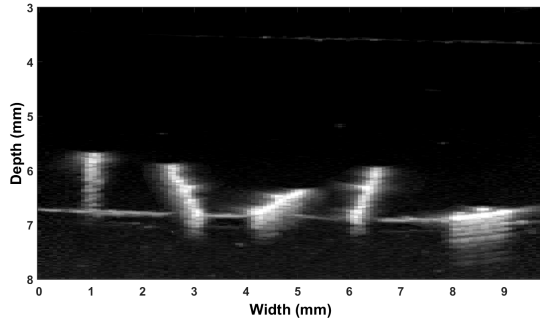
in vitro* Tests: Ultrasound B-mode motion lapse of microrobot moving through water in a 1% agarose tube over a 4 second time period.
